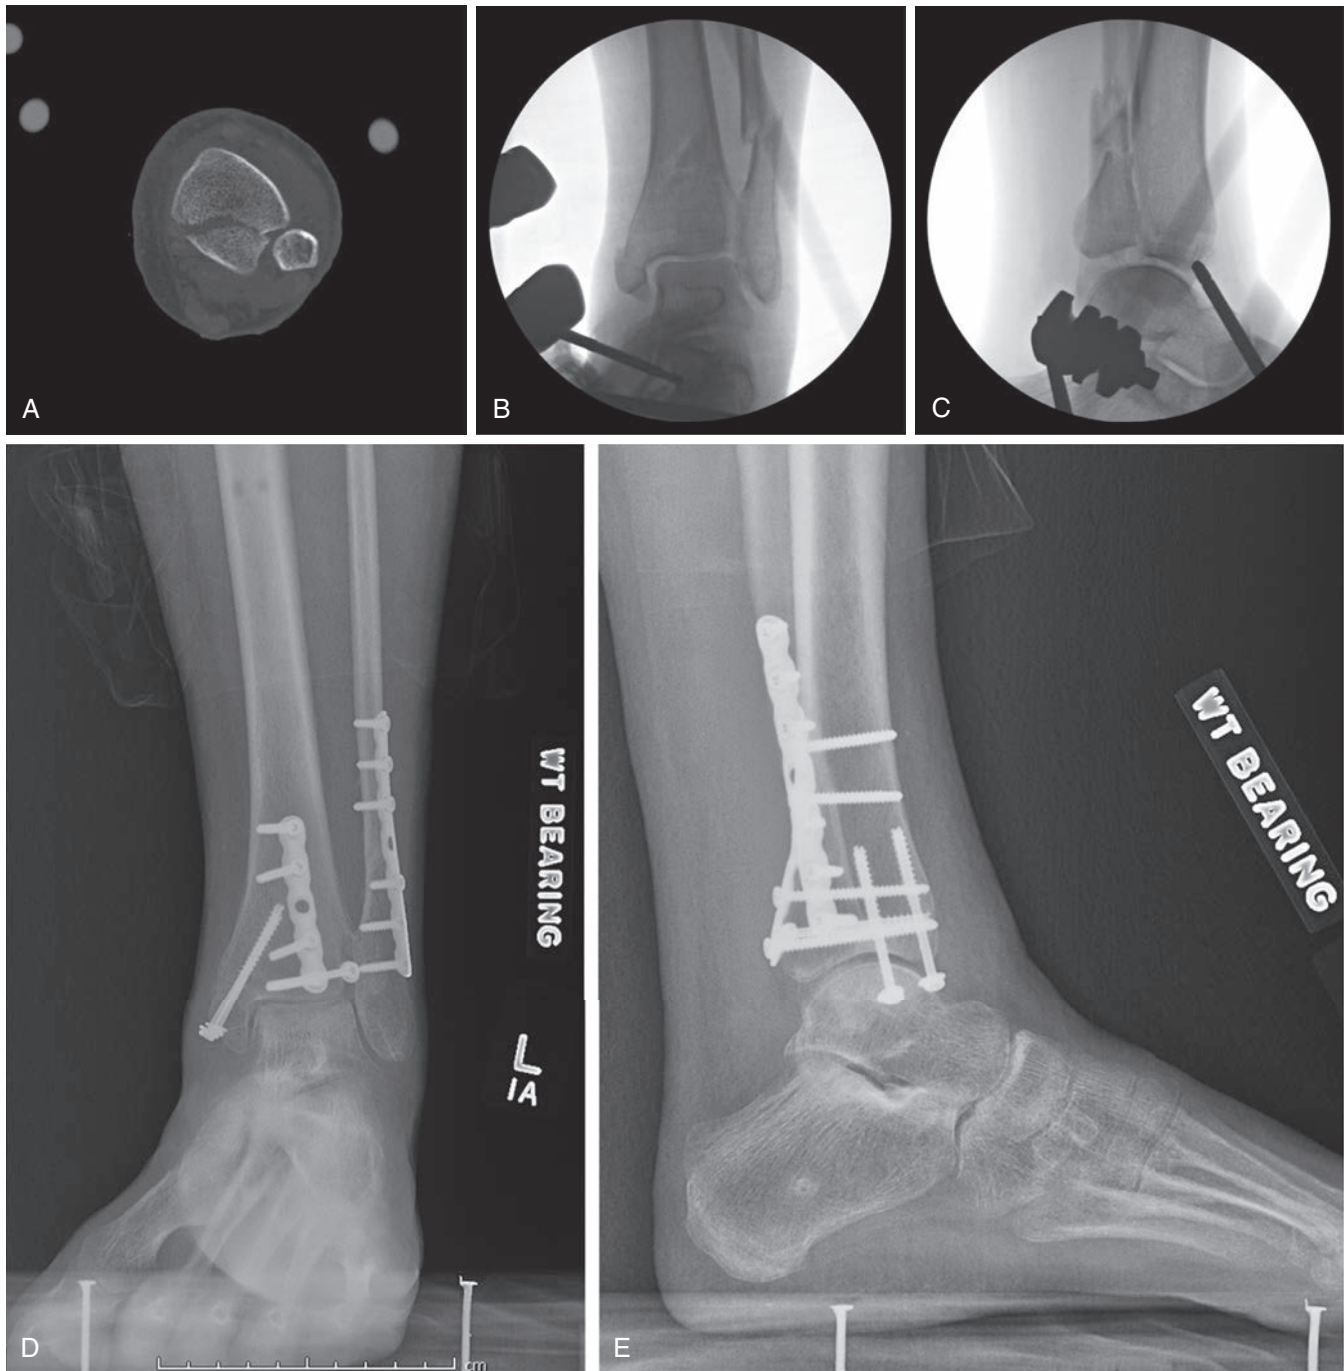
(A through E) (A) Displaced posterior malleolus fracture resulting in malalignment of the tibial incisura and syndesmosis. (B and C) Intraoperative radiographs showing a displaced trimalleolar ankle fracture. (D and E) Postoperative radiographs with buttress anti-glide plating of the posterior malleolus. Note the syndesmosis is stable after fixation of the fracture.
